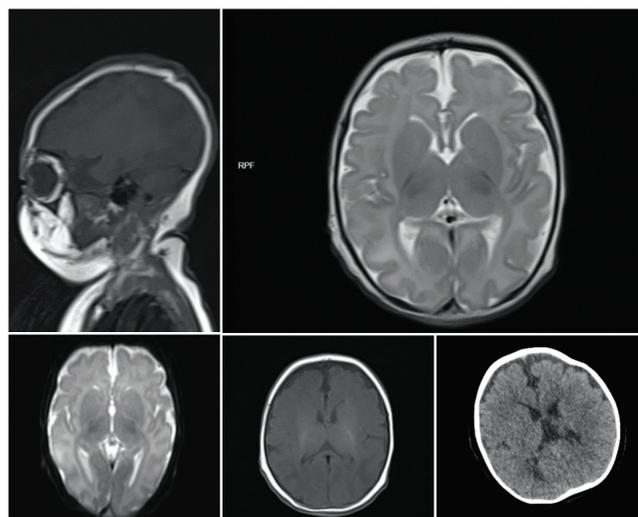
Brain magnetic resonance imaging of the patient at the age of three months old
